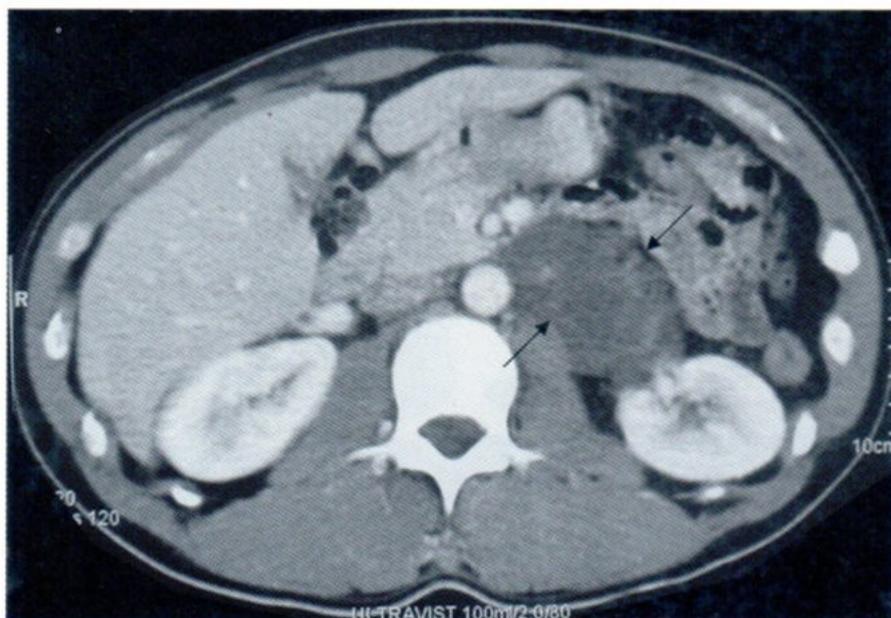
Third CECT study revealed no significant change as compare to the second CT study.
